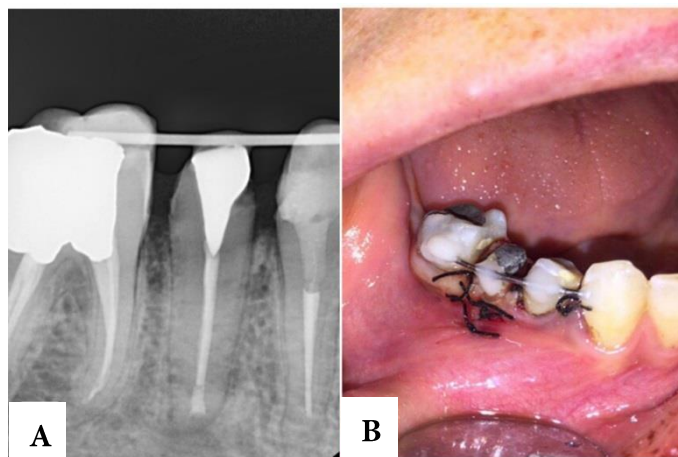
A) Periapical radiograph of the tooth after replantation; B) Clinical view of the tooth after replantation, stabilizing, and suturing
